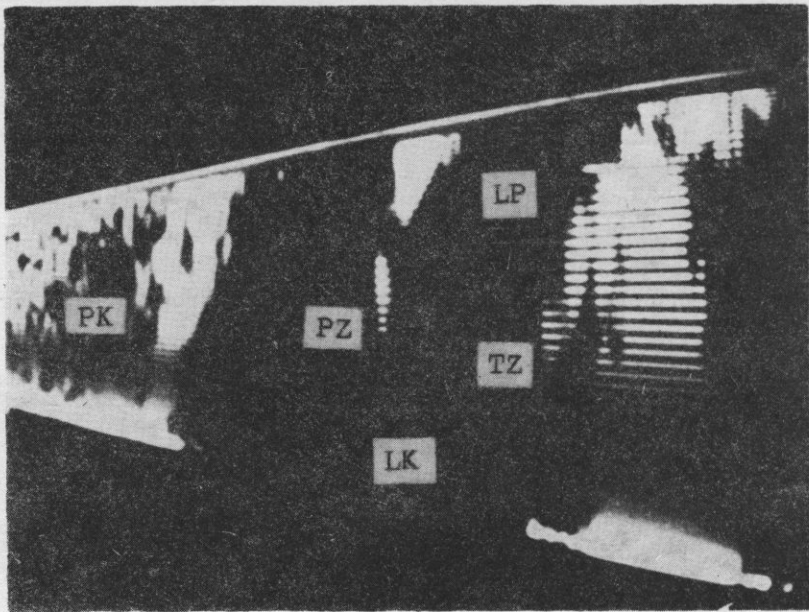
Ultrasonogram of the heart obtained in real time
